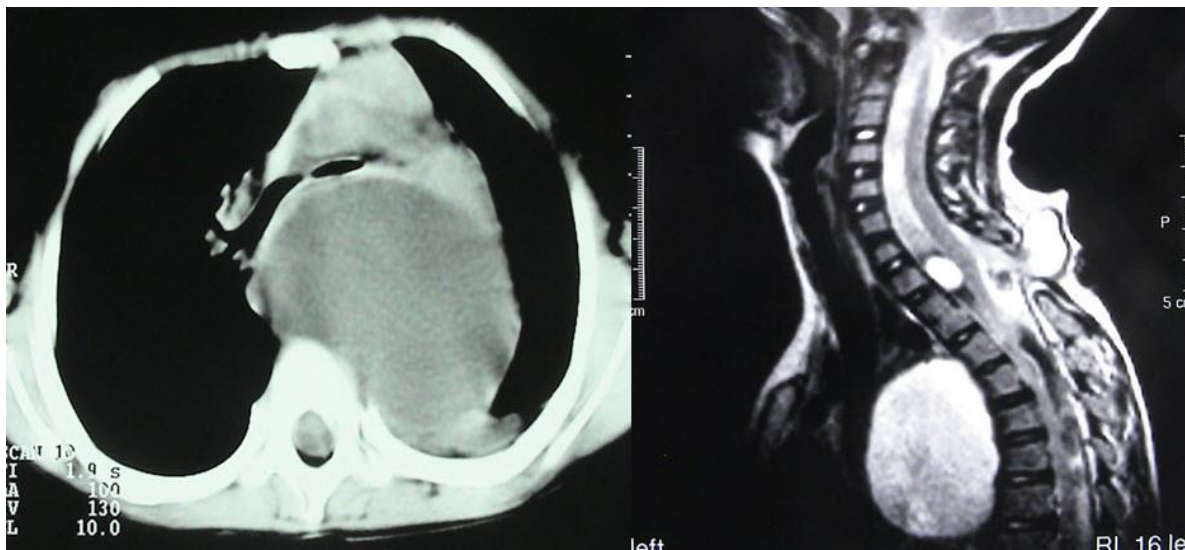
Chest CT scan shows a cystic mass in the left posterior mediastinum associated with cervicothoracic vertebral malformations.
